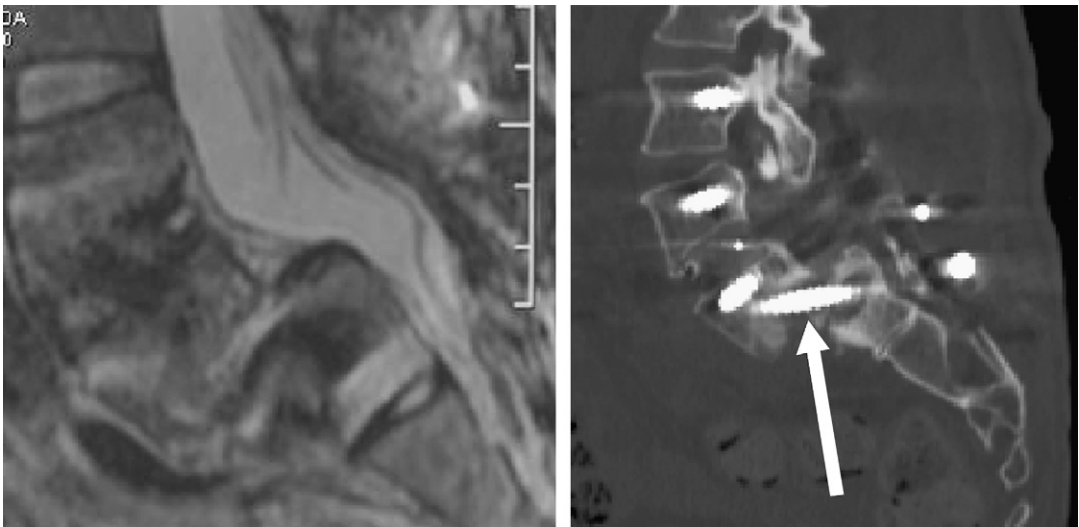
(*Left*) Sagittal T2-weighted MRI view of a 43-year-old woman with severe back pain and grade 4 L5-S1 spondylolisthesis who had undergone a prior failed fusion procedure. (*Right*) Sagittal CT reconstruction after placement of a transvertebral screw across the sacral promontory into the listhesed L5 vertebral body (*arrow*).
